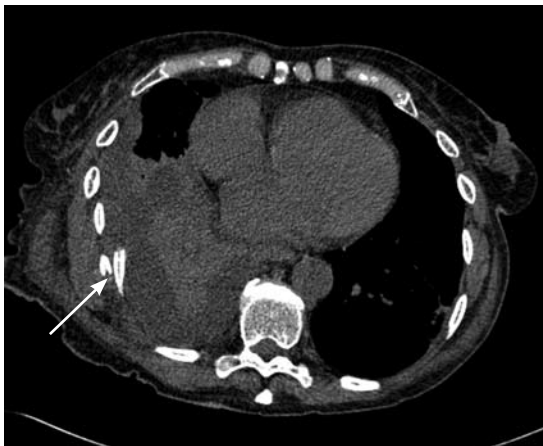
An axial image from a computed tomographic scan of the chest in a trauma patient shows a displaced fracture in a posterolateral right rib (arrow). There is an underlying effusion, the density of which indicates hemothorax. There is also a pulmonary contusion.
